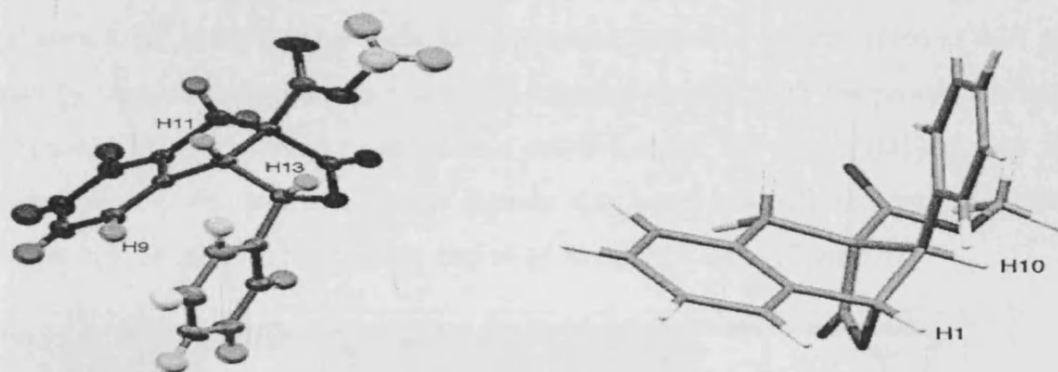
X-ray structure of 242a and optimized structure of 243a by calculations.
